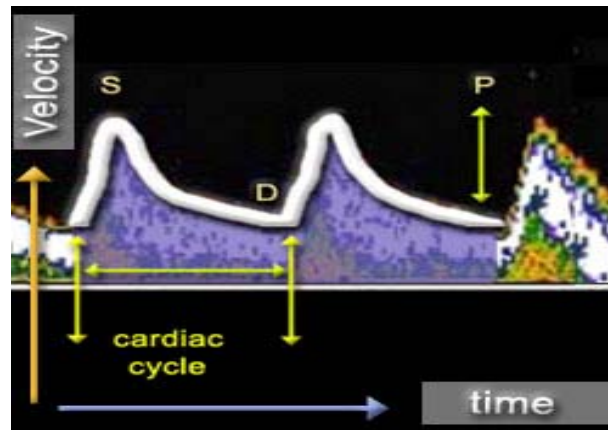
Arterial velocity sonogram (waveform).
